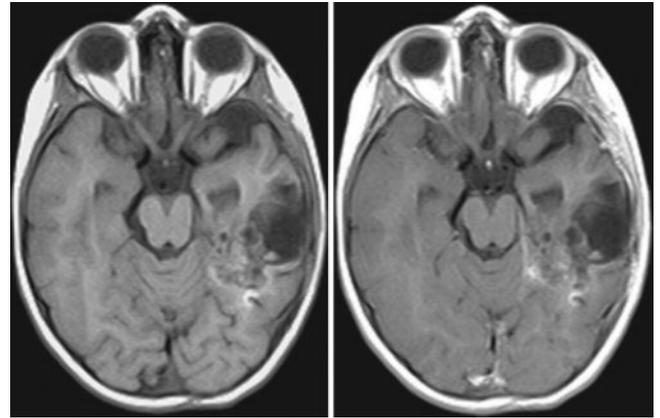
Axial T1-weighted MR images obtained before (left) and after (right) gadolinium administration, showing complete excision of the lesion at 9 months after surgery. An area of minimal hyperintensity in the posterior margin of the surgical site is present in both the images but has no pathological significance.
